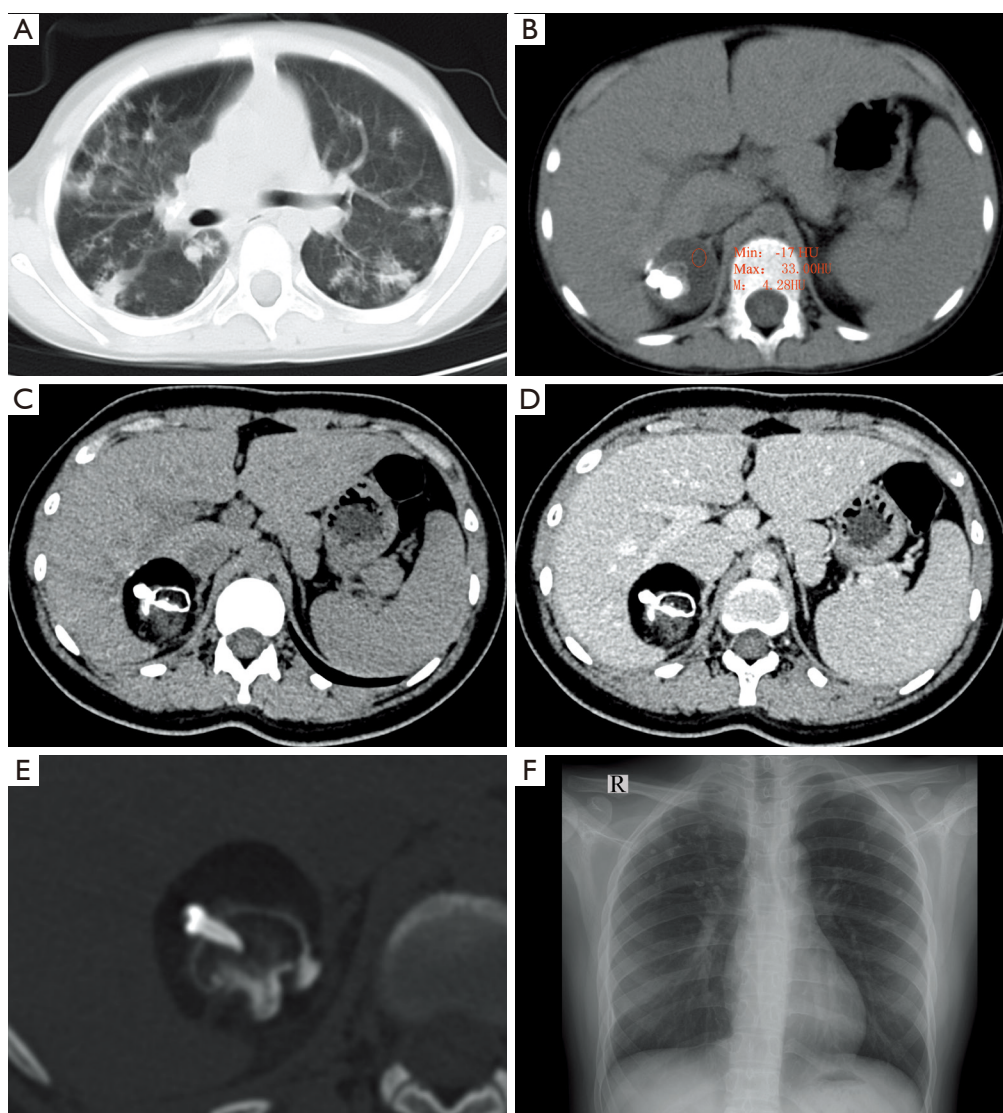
(A,B) A 17-year-old woman at the age of 8. (A) Multiple patchy and nodular high-density shadows in the middle lobe of the right lung and upper lobes of both lungs, some of which were accompanied by punctate calcification [window width (WW) 1,382, window level (WL) -360]. (B) A spherical mass in the right adrenal region, with predominantly liquid density and multiple calcifications in the mass (WW 246, WL 65). (C,D,E,F) A 17-year-old woman, CT image of upper abdomen. (C) Right adrenal mixed density mass with fat, soft tissue and calcification (WW 220, WL 40); (D) enhanced scan showed mild enhancement of soft tissue in the mass (WW 220, WL 40); (E) three-dimensional reconstruction showed there was tooth-like high-density in the mass (WW 2,612, WL 960); (F) chest X-ray, multiple patchy and nodular high-density shadows in both lungs.
